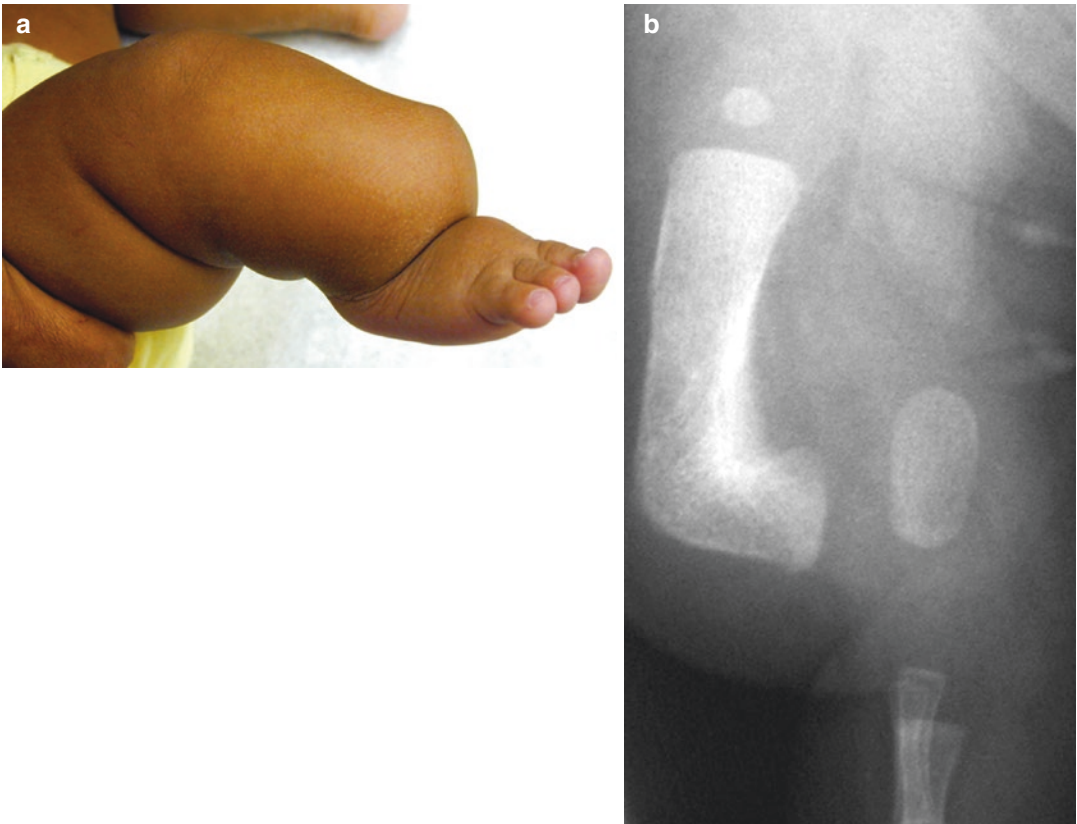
(a, b) Clinical and radiographic appearance of a child with anteromedial bowing associated with longitudinal deficiency of the fibula
